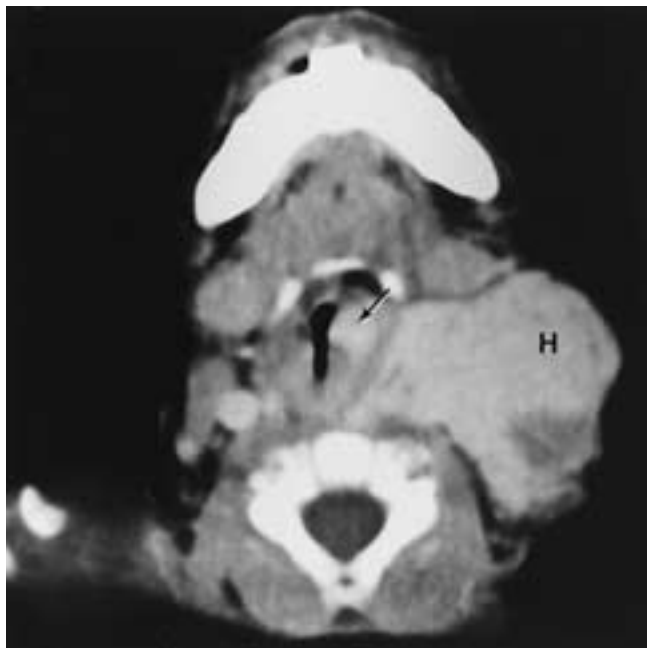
Axial CT of a child with large hemangioma (*H*) involving the soft tissues of the neck, with involvement of the AE fold and supraglottic paraglottic space (*arrow*).
